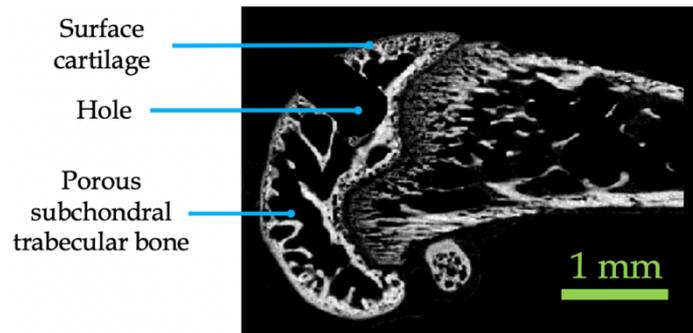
CT scan of drilled hole at the end of the femur bone
